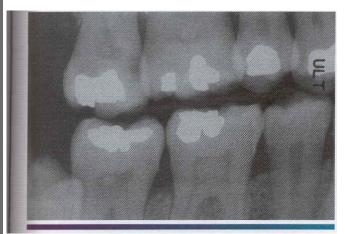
• Pulp stones. Multiple teeth demonstrating radiographically obvious calcifications within the pulp chambers.
